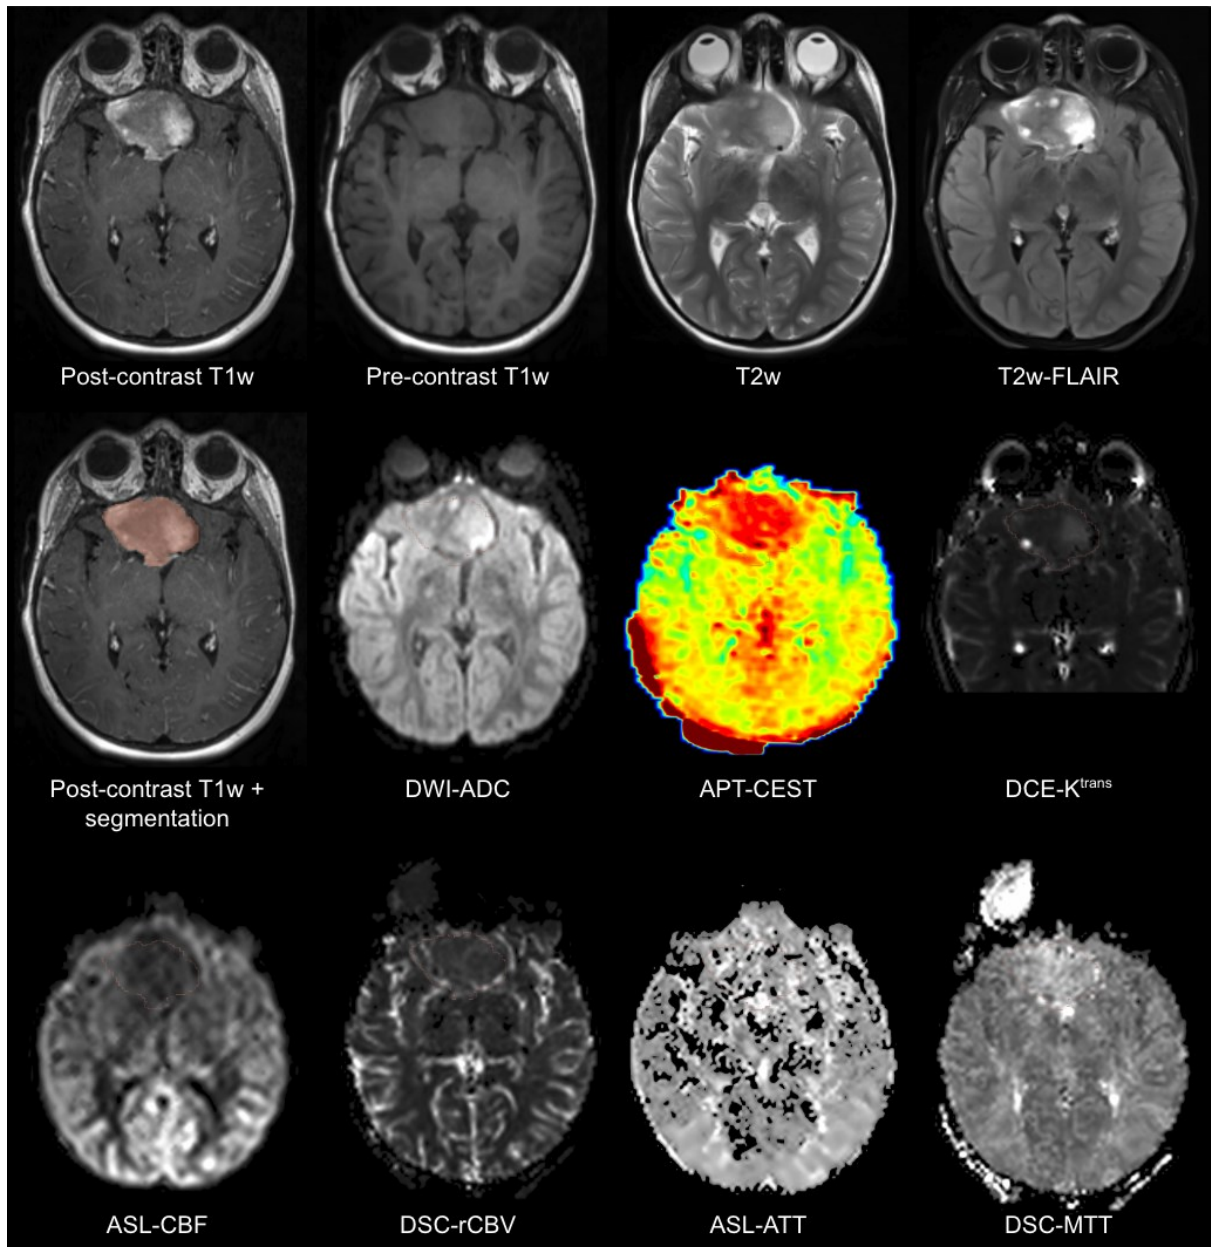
Structural (pre- and post-contrast T1w, T2w, T2w FLAIR, and DWI), molecular (APT-CEST) and perfusion (DCE, ASL, and DSC) follow-up scans of a pediatric patient with a WHO grade 1 pilocytic astrocytoma following initiation of chemotherapy. ASL was performed using a sequential multi-delay protocol.
